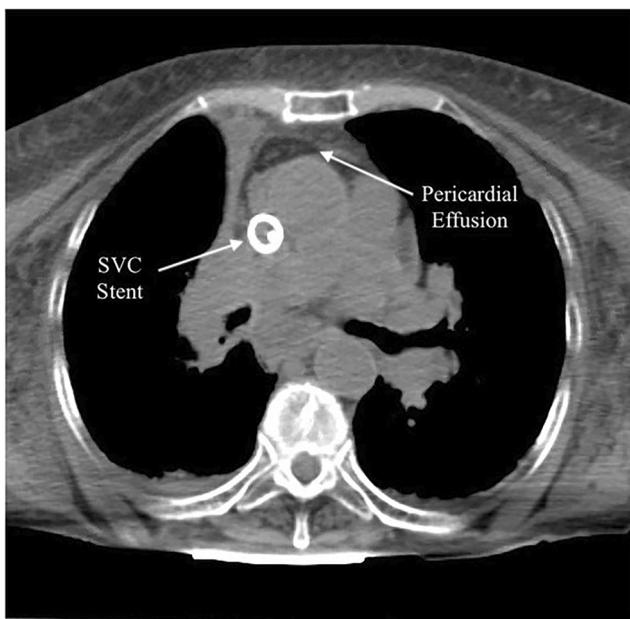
Chest CT scan. Post SVC stent placement. New pericardial effusion
